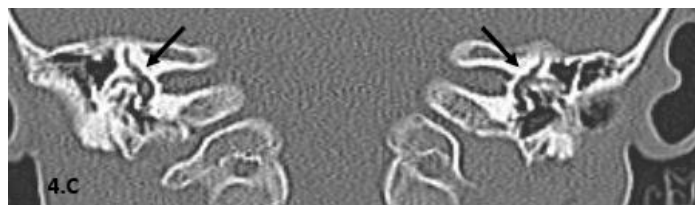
C: coronal CT view, bone window revealed normal bilateral SCCs (black arrows).
